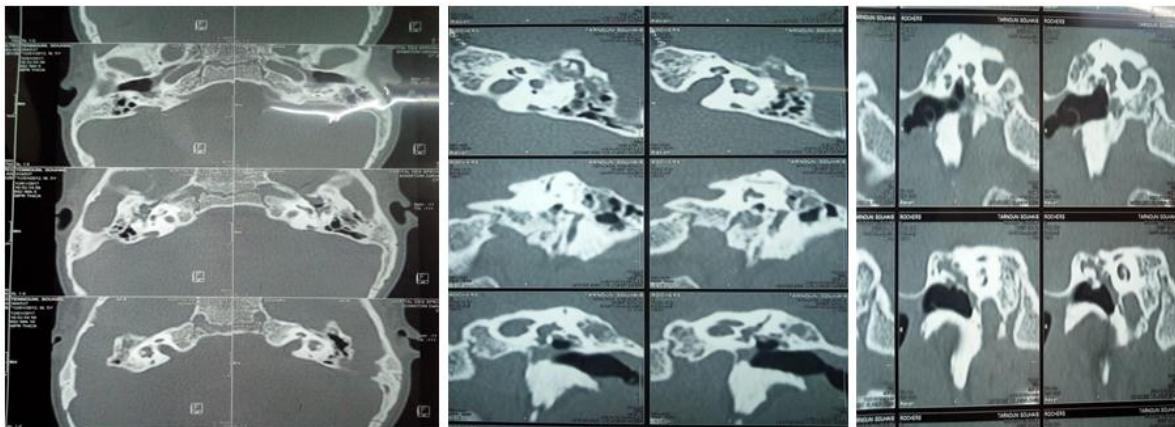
CT images with gadolinium injection in axial sections showing the different malformations of the inner ear on both sides
